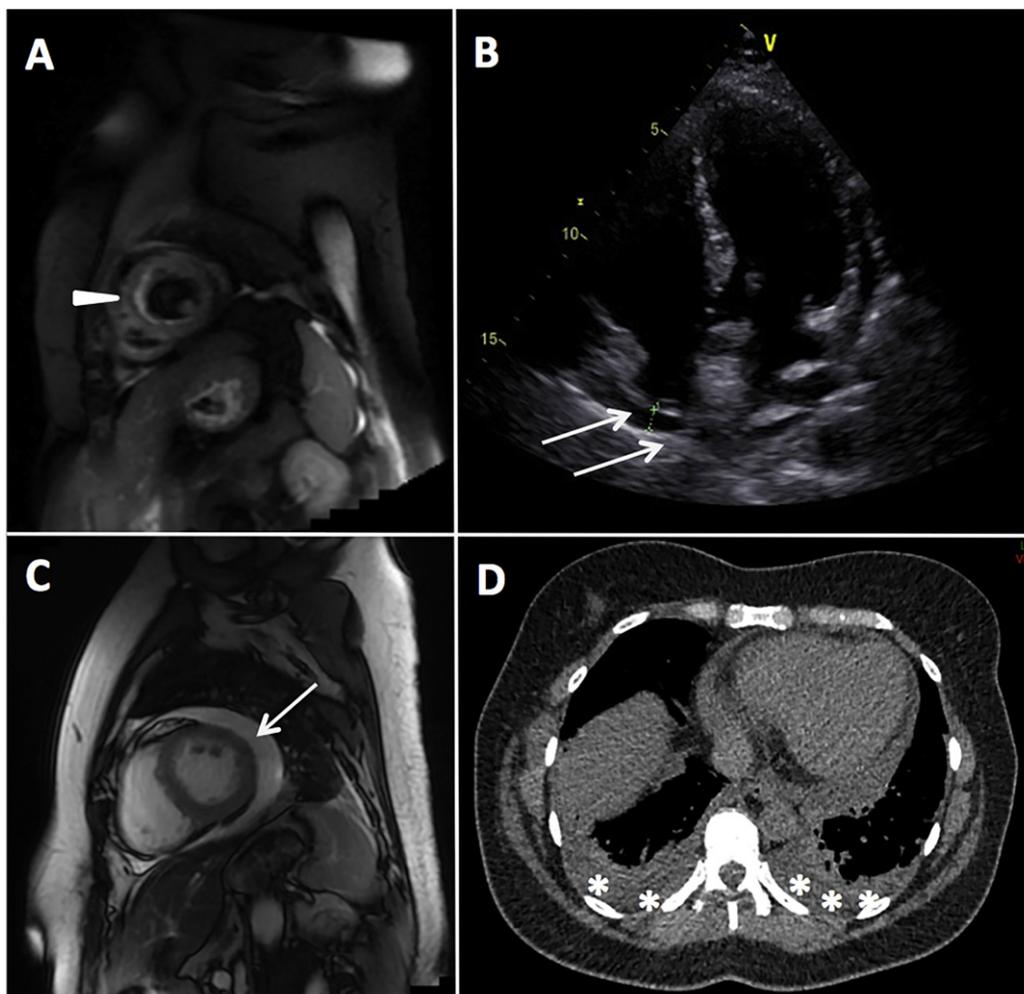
Imaging features of the myopericarditis. A. MRI of heart showing hypersignal T2 with gadolinium-enhancement (arrowhead) of myocardium suggesting of myocarditis. B–C. Echocardiography and MRI with T1 weighted sequence-revealing pericarditis (arrows). D. CT-scan of lung in axial view showing bilateral pleural effusion (asterisk).
